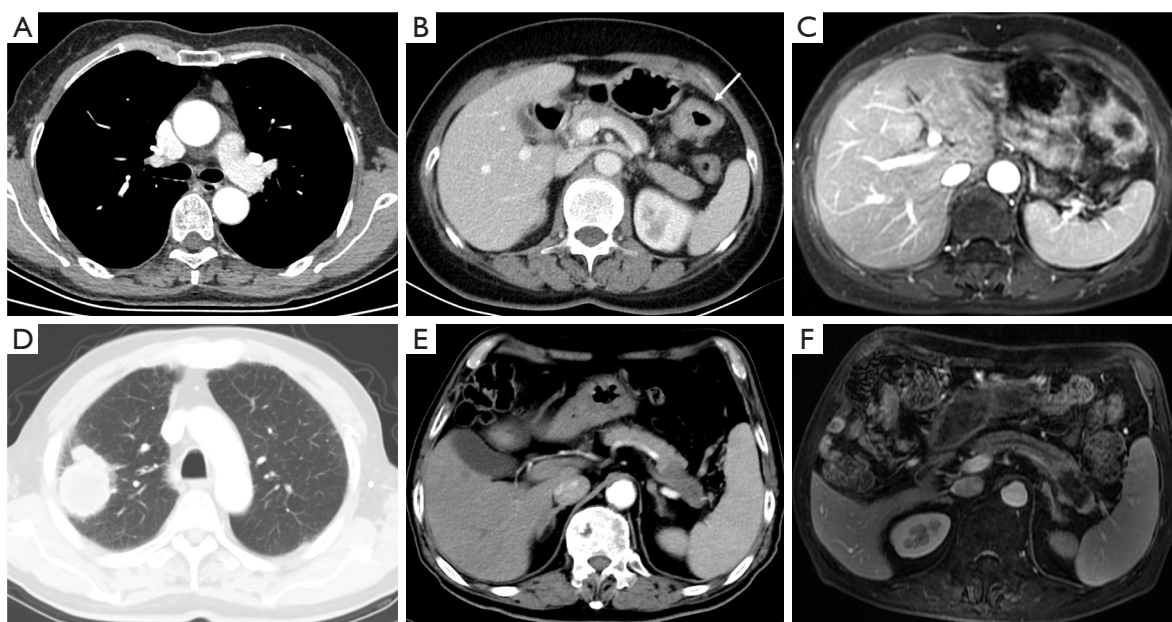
Blind spot on chest CT: the upper abdomen. (A-C) A 54-year-old female after resection of a thymic cyst in the anterior mediastinum. (B) The thickening of the colonic splenic flexure was missed on chest CT (arrow). During the follow-up period, she was diagnosed with colon cancer through colonoscopy. Subsequent MRI also revealed thickening of the colonic splenic flexure wall. (D-F) A 71-year-old male with lung cancer in the right upper lung lobe. (E) CT image showing an ill-defined mass in the pancreatic tail, which was initially missed. (F) MRI images revealing the same mass with an abnormal signal; the degree of enhancement on the enhanced scan was lower than that of the normal pancreas, and the splenic artery and vein were involved, suggesting pancreatic cancer. CT, computed tomography; MRI, magnetic resonance imaging.
